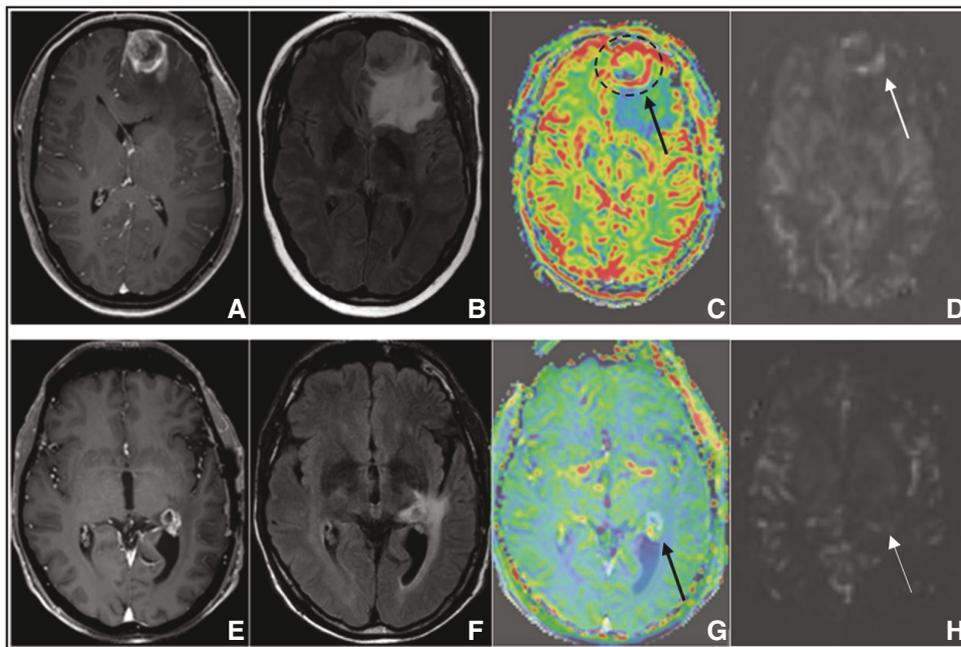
Example post-contrast T_{1w} images (A + E), T_2 FLAIR images (B + F), DSC-rCBV maps (C + G) and ASL-CBF maps (D + H) for 2 example cases with confirmed tumor progression (A–D; top) and pseudoprogession (E–H; bottom).
